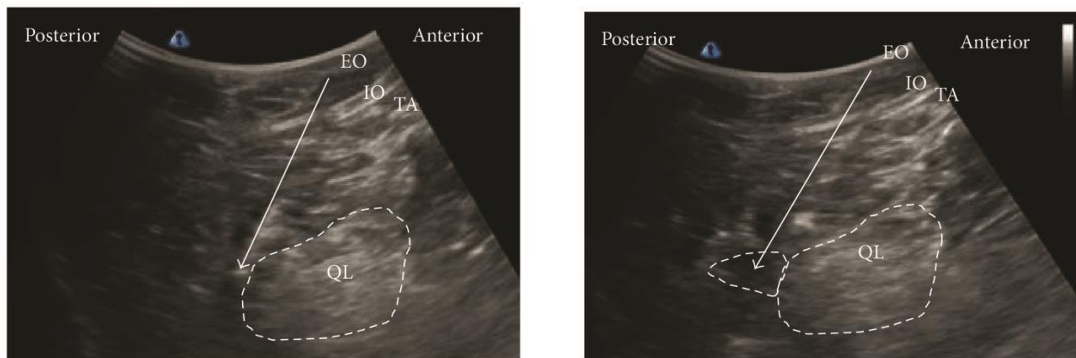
Ultrasound images of posterior QLB. (a) Preinjection and (b) postinjection. EO: external oblique muscle, IO: internal oblique muscle, TA: transversus abdominis, QL: quadratus lumborum, white arrow: needle trajectory, and white dotted line: spread of local anaesthetic.
